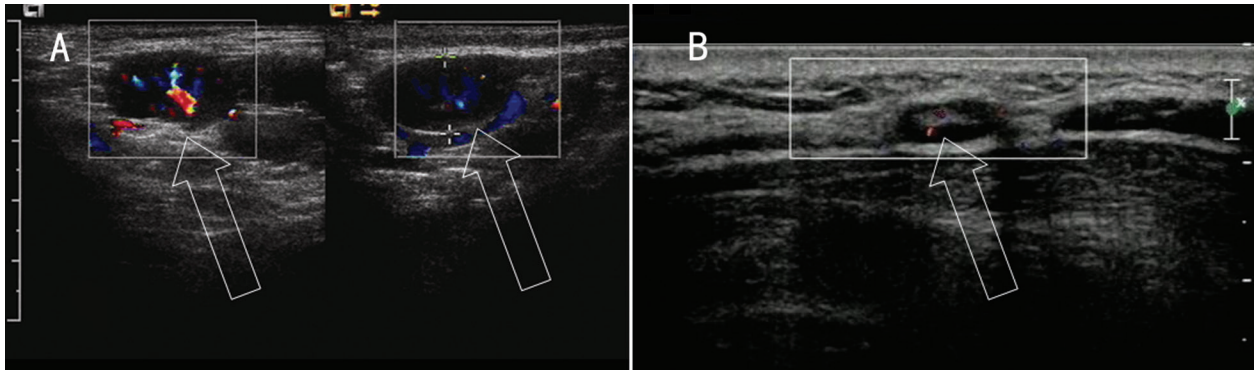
Color Doppler flow imaging of HV type of CD in the right neck revealed increased blood flow with signal abnormality resembling many branches of thick wall vessels in and around the lesional lymph node (A) compared to the Color Doppler flow imaging of normal lymph node (B).
